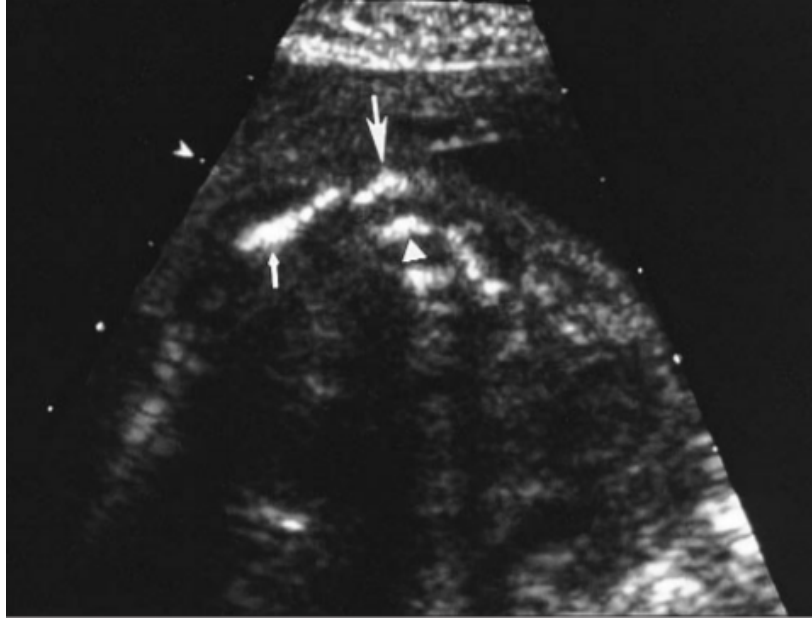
Axial ultrasonogram of the fetal low cervical spine. Note the symmetric lamina of the depicted cervical vertebral body. The scapula is elevated (short arrow) , and the omovertebral bone (long arrow) is interposed between the scapula and the cervical vertebra (arrowhead)
